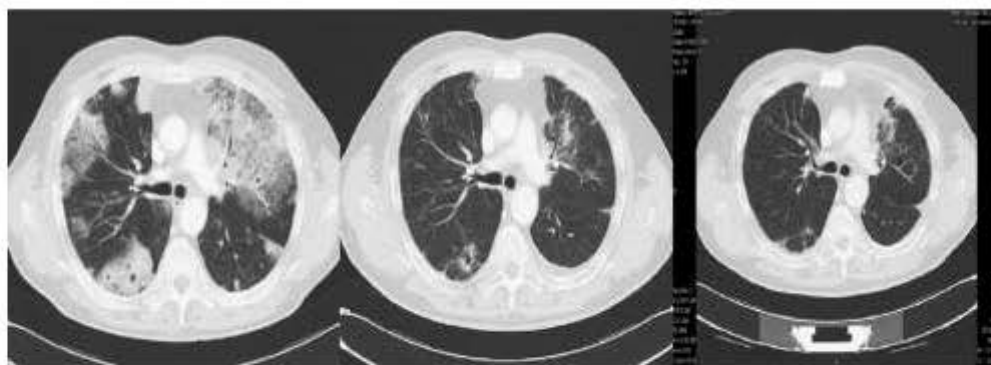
Chest CT images show radiological complete response after 6 and 12 pemetrexed cycles.
